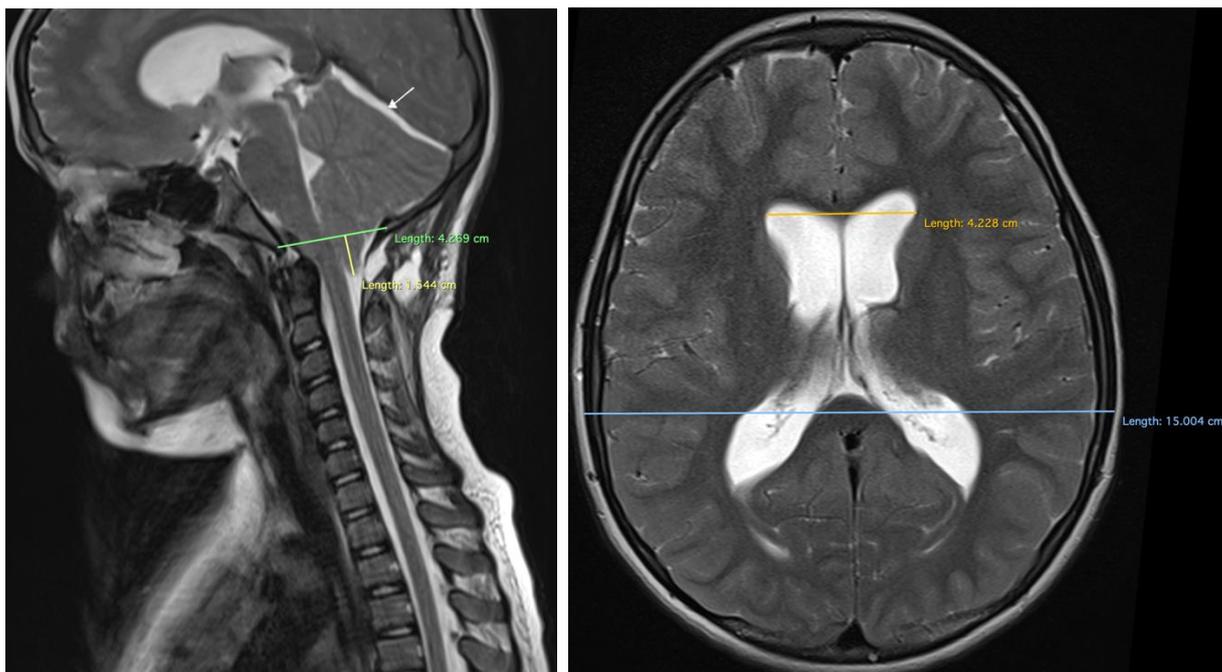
a) Sagittal and b) axial T2-weighted MRI scans obtained 4 weeks post-FMD. (a) (white arrow) revealing infratentorial hygromas, pseudomeningocele and a cerebellar ptosis. (b) showing the enlargement of lateral ventricles and an Evans index estimated at 0.28. Of note, no suboccipital craniectomy was performed to alter the opisthion.
